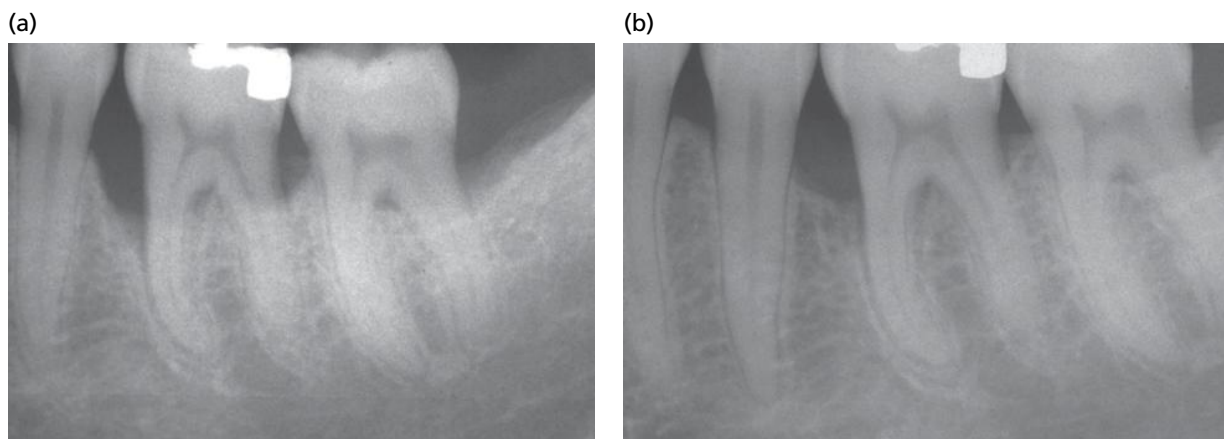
Radiographs of the patient presented in Fig. 32-2 at the final re-evaluation.
